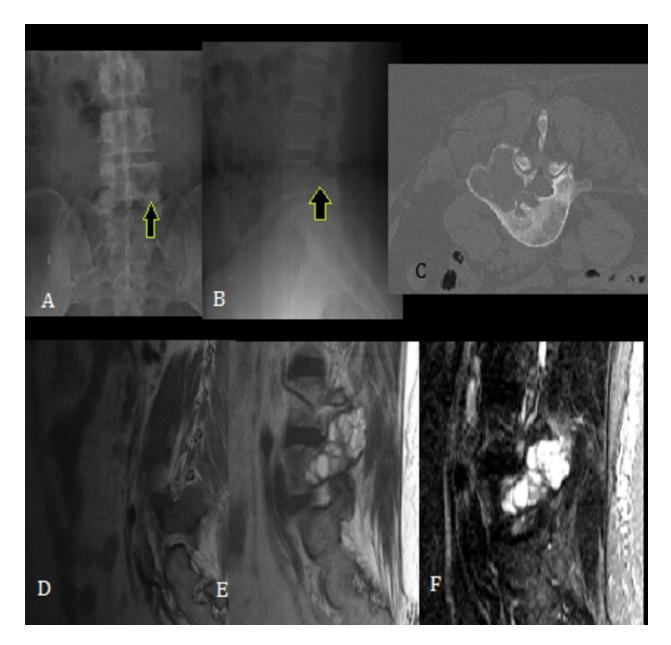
Aneurysmal Bone cyst. Frontal and lateral radiographs (A, B) reveals a sharply demarcated lytic lesion in the left hemi body of the fifth lumbar vertebra (arrow). Axial computed tomography reformation image (C) shows a large expansible lytic lesion involving the left hemi body and posterior elements, without any evidence of periosteal reaction and with cortical disruption. Sagittal T1 and T2 weighted images (D,E), sagittal T2 turbo inversion recovery weighted image (F) show a lesion located in the pedicle, transverse apophasis and body of the fifth lumbar vertebra. The lesion expands beyond the bony limits and has a small endocanalar component without frank compression of the dural sac. This lesion presents a multiloculated appearance, with fluid-fluid levels and highly heterogeneous signal intensity on T2-weighted images and low intensity of signal on T1 weighted images.
